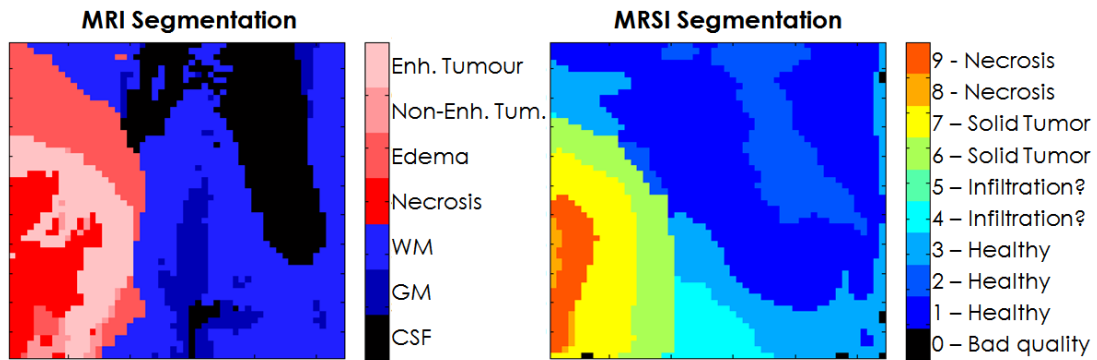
Comparison between the MRI and MRSI segmentations for one of the cases included in the test-set. MRI segmentation performed using BratumIA.
